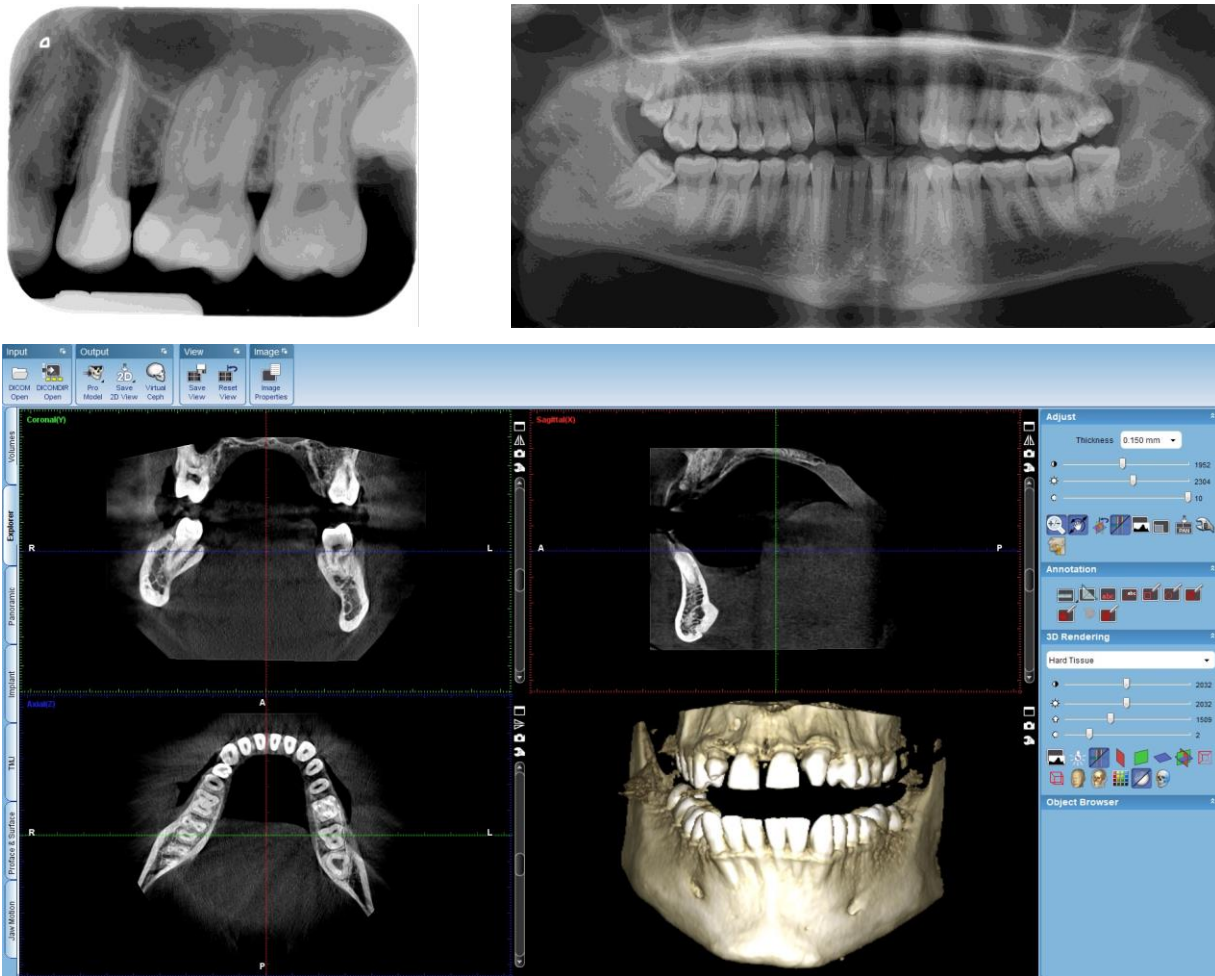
Examples of intraoral radiographs, panoramic radiographs, as well as 3D CBCT images obtained with the X-ray equipment available.
